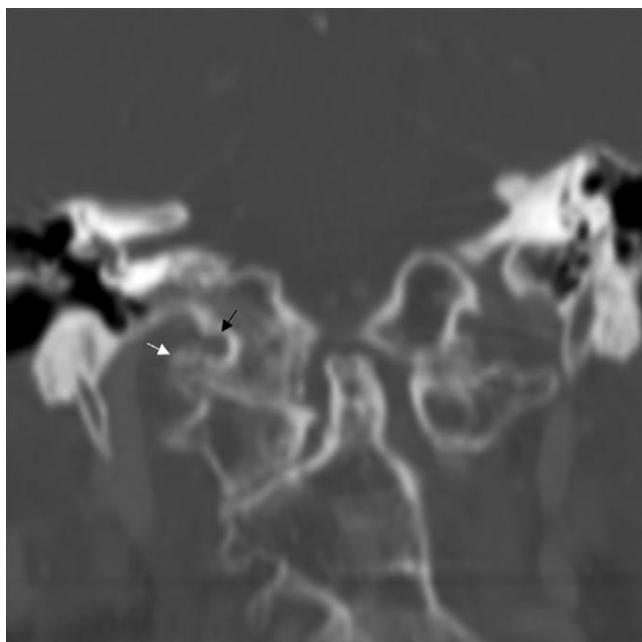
CT reconstruction of the cervico-occipital hinge, coronal slices. Note proximity of the osteophyte (white arrow) to the external orifice of the right hypoglossal canal (black arrow).
